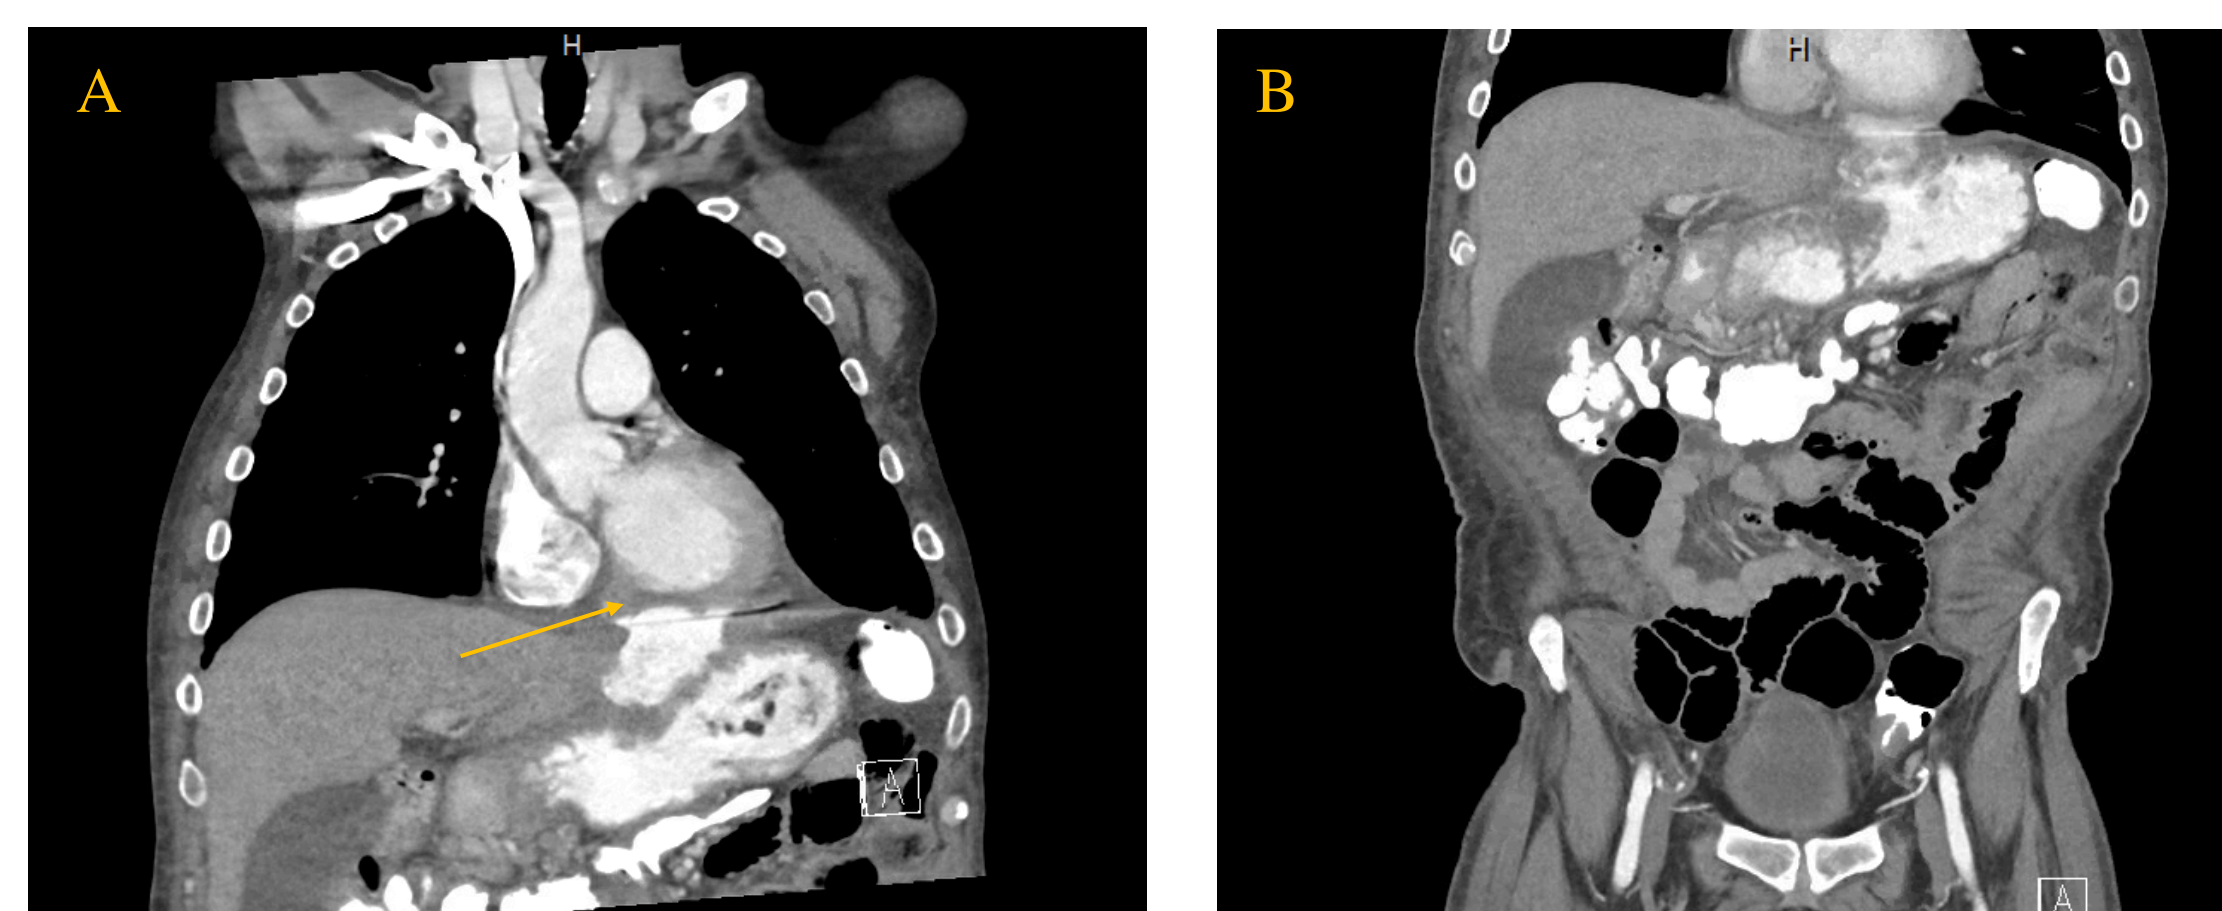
CT chest with IV and oral contrast (10/18/2022). (A) Arrow indicates a thinned myocardium over the left ventricle which is directly adjacent to a contrast-filled stomach. No contrast in the pericardium. (B) Visualization of known gastro-gastric fistula.
